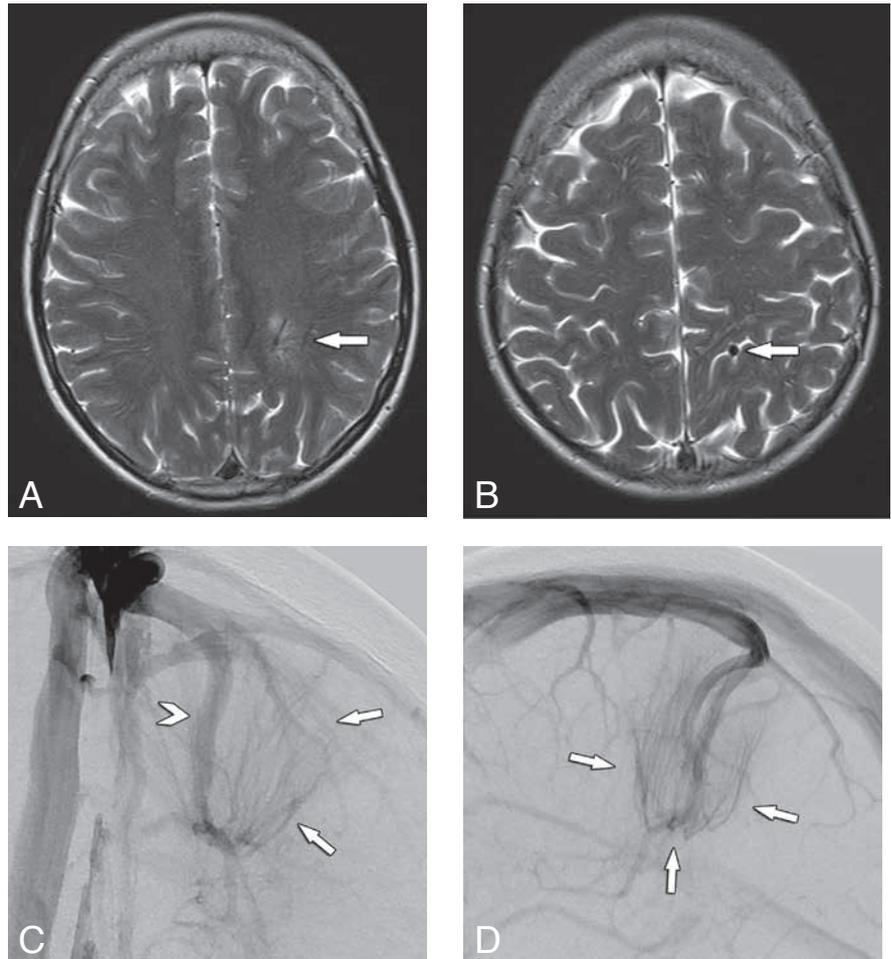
Axial T2-weighted MR-images showing a focus of abnormal signal in the left parietal lobe (A) with a flow void running transcerebral, suggestive for a vascular malformation (B). Anteroposterior (C) and lateral (D) cerebral angiography, venous phase, show the typical appearance of a DVA in the left parietal lobe with the caput medusae of dilated medullary veins (arrows), accompanied by a single, large draining vein that drains in the superior sagittal sinus (arrowhead).
